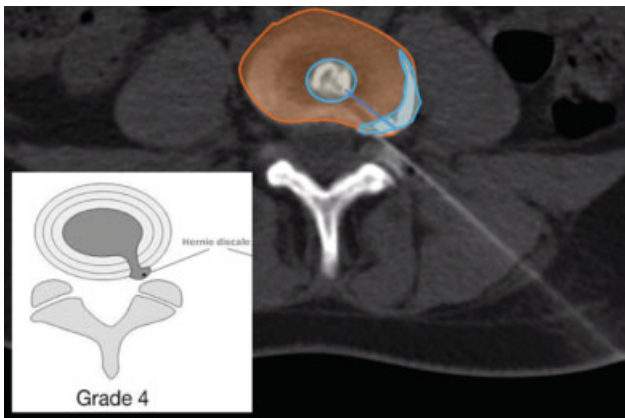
The procedure is performed under dual guidance with fluoroscopy and CT. The needle path is planned to pass in the lower portion of the foramen.
